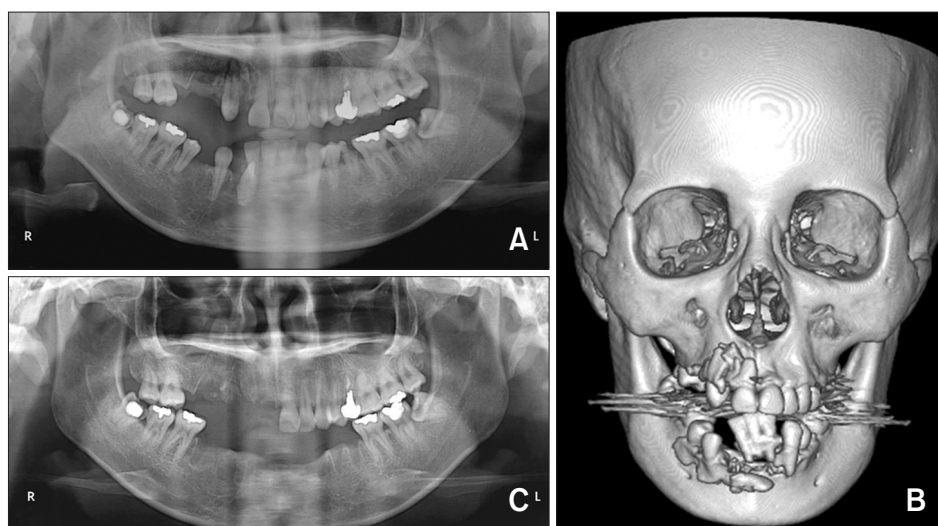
(A) Preoperative panoramic radiography shows alveolar fracture, teeth avulsion and teeth fracture. (B) Preoperative computed tomography (CT) image shows alveolar bone fracture on both jaws. (C) Postoperative panoramic radiography image shows good healing of the surgical site.
